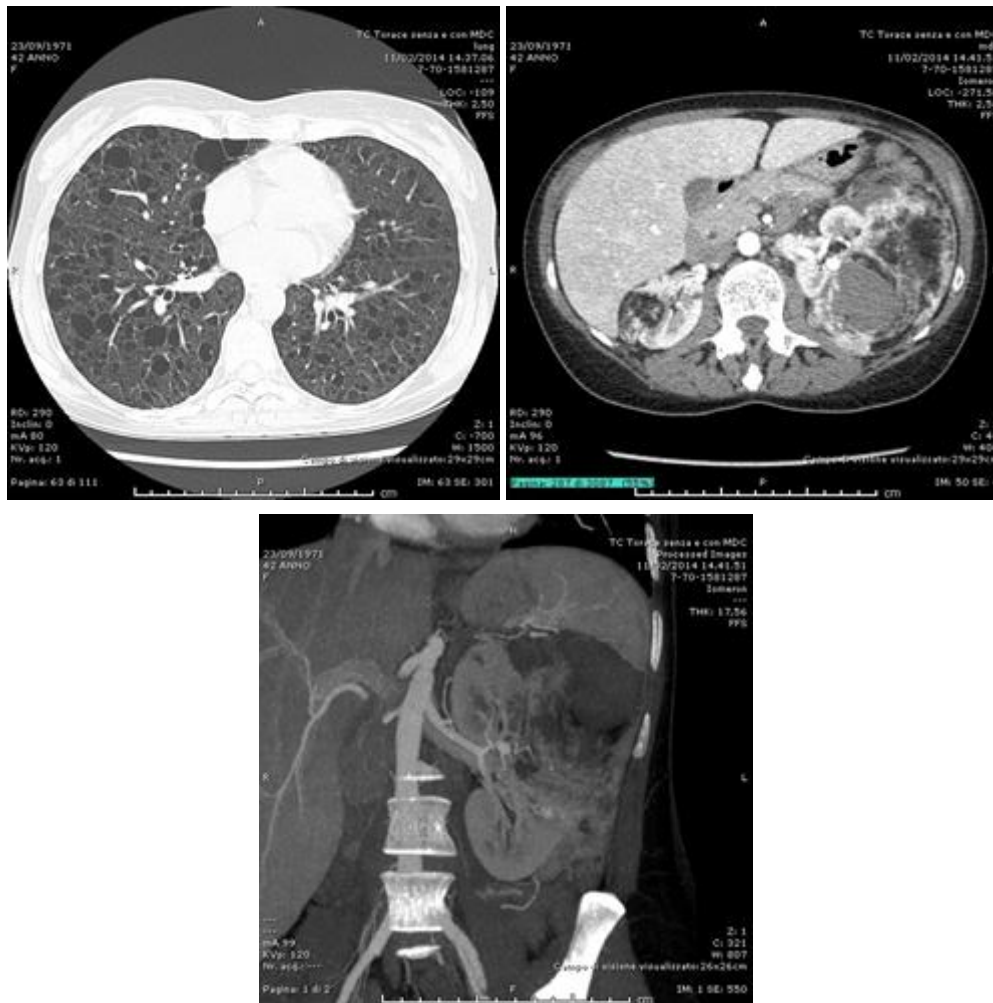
Computed tomography (CT) scan at presentation showed a-c): Multiple cysts, with ubiquitous distribution, within lung normal parenchyma. Signs of atypical resection are evident. d, e) Left kidney angiomyolipoma with past bleeding, along with pseudoaneurysms.
